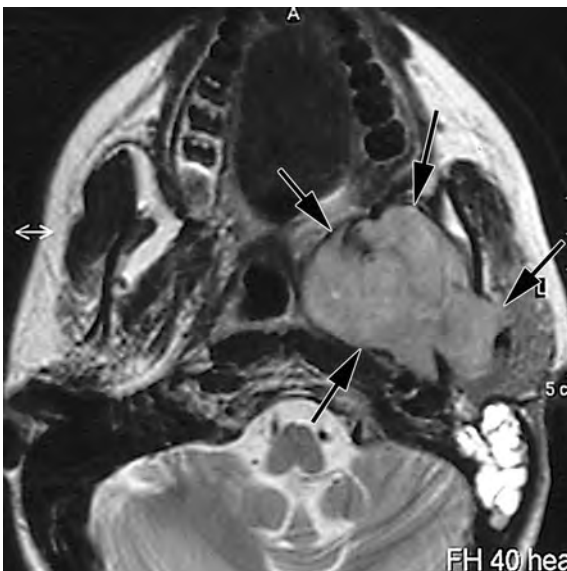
Axial T2-weighted (a) and plain T1-weighted spin echo image (b) in a 22-year-old patient presenting with hearing loss on left side and increasing difficulties with mastication. A soft tissue mass (*black arrows*) is seen on deep side of mandible, extending into the PPS; a thin layer of fat can be recognized on the posteromedial side of the mass (*white arrow*). The lesion involves the deep lobe of the parotid gland. Contrary to the patient shown in Fig. 4, the pterygoid musculature cannot be recognized anymore, suggesting that the point of origin is within the masticator space. Fluid is present in the mastoid, secondary to dysfunction of the eustachian tube. Biopsy revealed rhabdomyosarcoma
